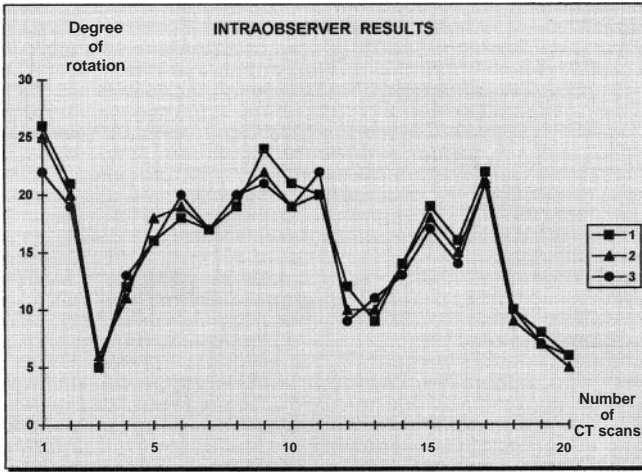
Intra-observer measurement results of the new CT measurement method
